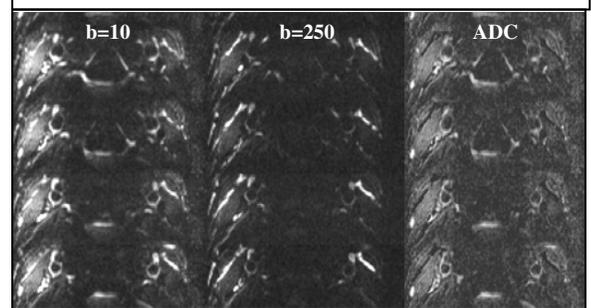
DWI from normal volunteer. The ADC map were calculated using b=0, 250 sec/mm². All DW images demonstrate the good blood suppression.
